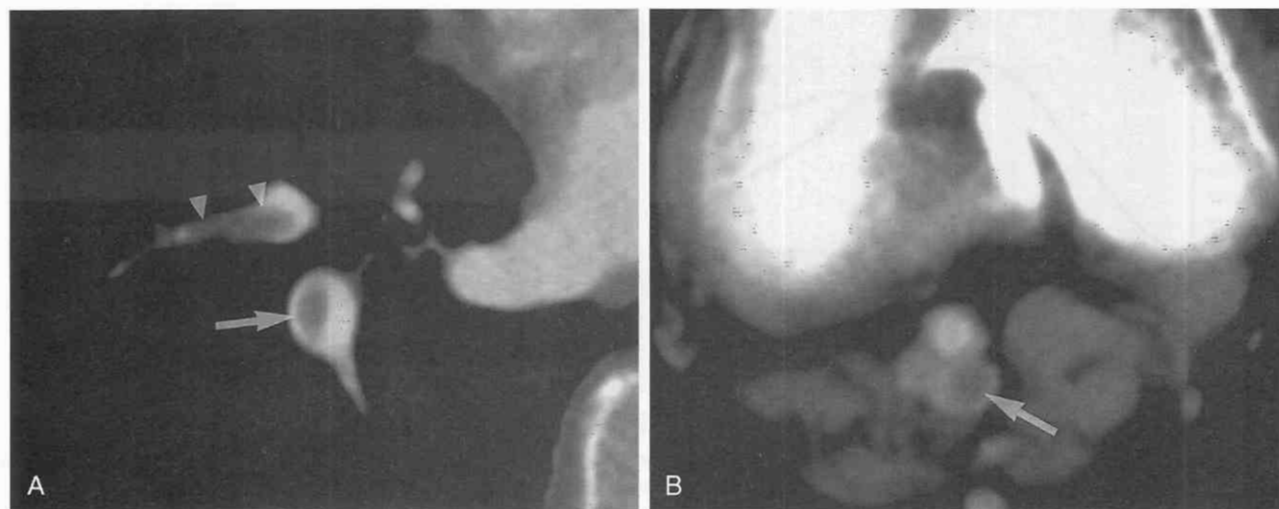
Pulmonary emboli and deep venous thrombosis. *A*, Multislice helical CT of the chest was completed in 15 seconds with 2.5-mm slice width. Emboli are seen within two segmental arteries: one oriented in the cephalocaudal direction (arrow) and the other in the transverse direction (arrowheads). *B*, The pelvis and legs were scanned beginning 2.5 minutes after the start of contrast medium injection; popliteal venous thrombosis (arrow) is seen.
